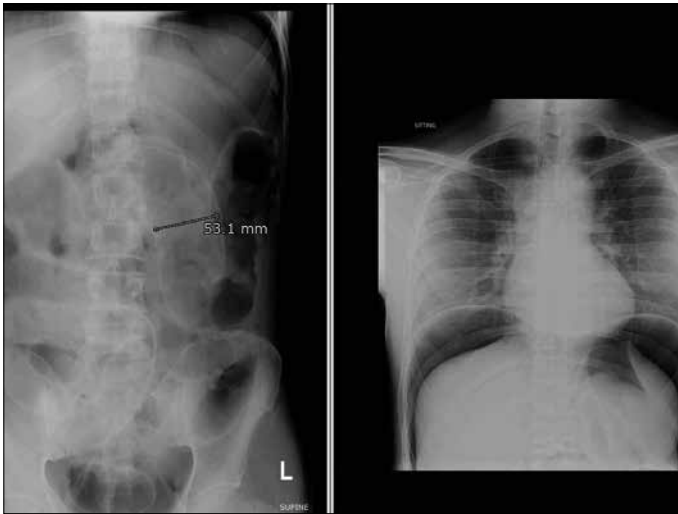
Supine chest X-ray and upright abdominal film showed the presence of pneumoperitoneum with distention of the colon
